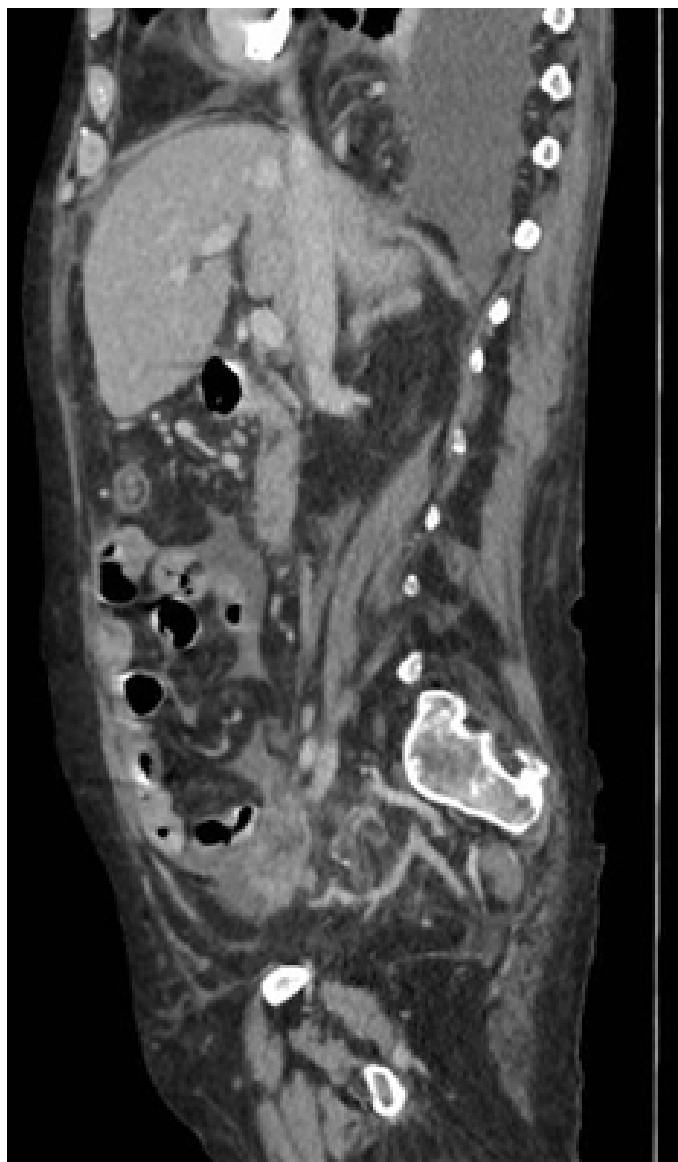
Sagittal CT scan of the abdomen showing an intrathoracic collection. Other collections are also seen at the retrogastric level, in the tail of the pancreas and in the splenocolonic ligament with no signs of complication.
